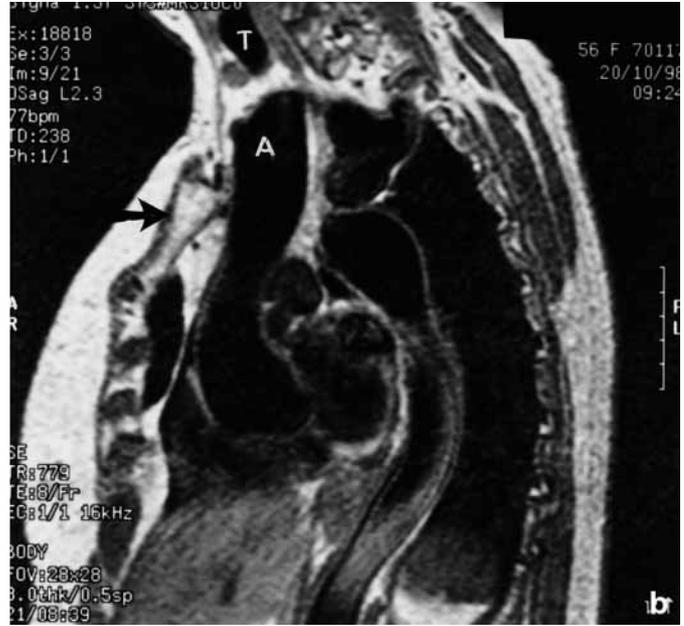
MRI scan of the same patient in Fig. 5a but taken as an oblique sagittal slice. It shows the aorta climbing above the manubrium (black arrow) into the suprasternal region. Part of the trachea is visible (T) on this view. A – cervical aorta.
